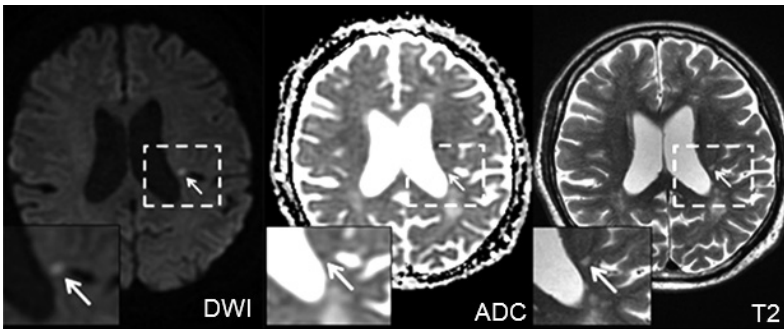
Example of an acute cerebral microinfarct (white arrow) on 3 tesla MRI, being hyperintense in DWI, hypointense on ADC and hyperintense on T2*.
